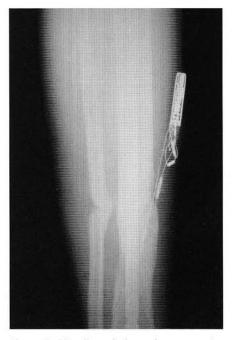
AP radiograph 6 months postoperative with complete union of tibia.
